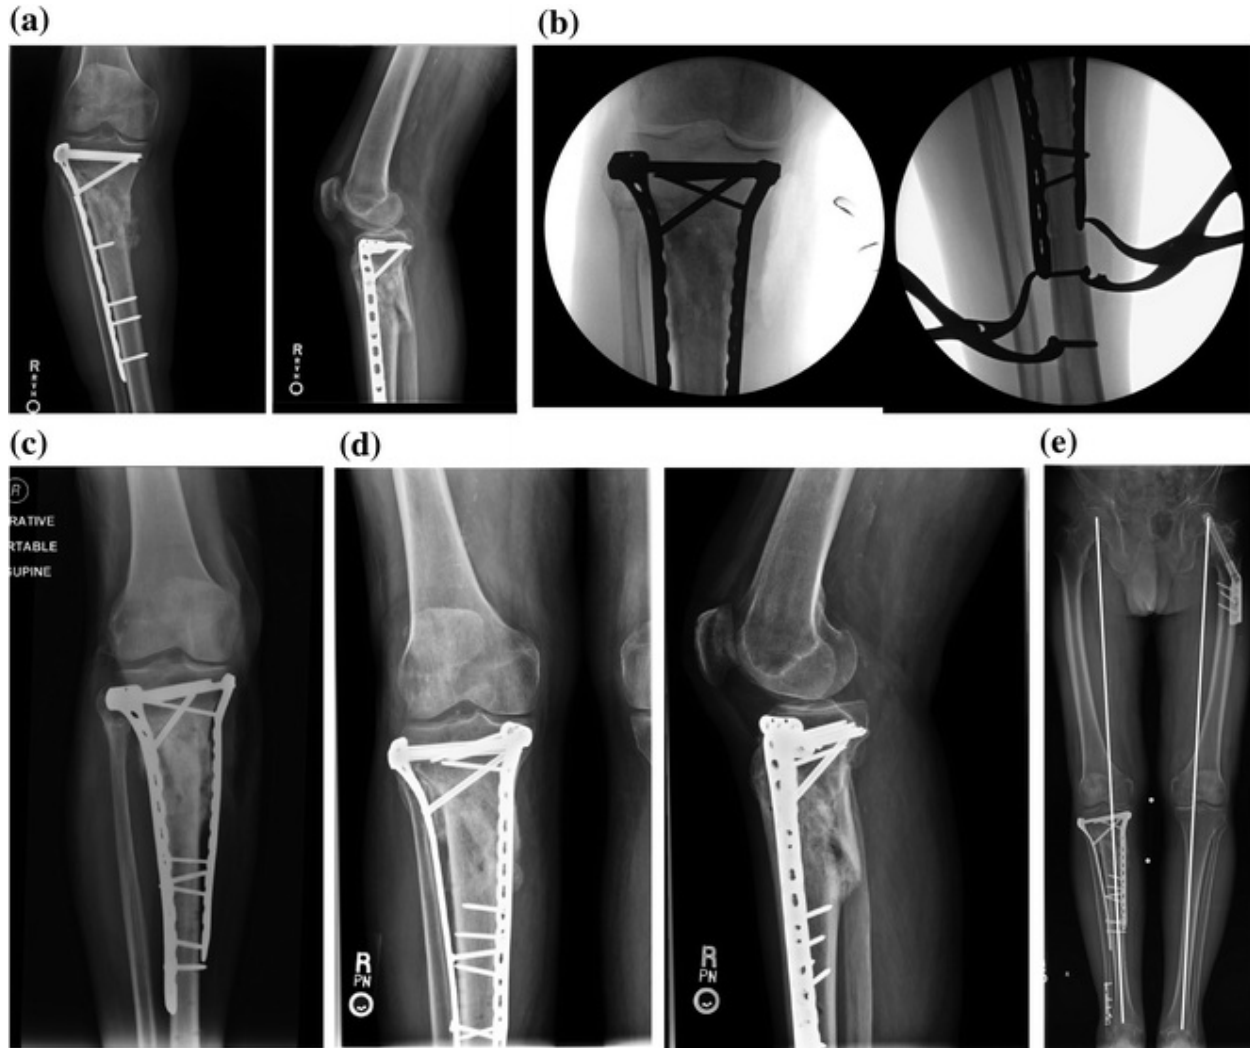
a Presenting films demonstrate varus deformity that was progressive since the time of his initial stabilization in near-anatomic alignment. Sagittal plane alignment appears good. b After establishing locking fixation in the proximal segment medially and laterally, compression and fine-tuning of alignment were achieved with medial and lateral Verbrugge clamps and push-pull screws distally. c Intraoperative plain films are taken on 17" × 14" cassettes to confirm coronal plane alignment with a larger field of view than offered by the fluoroscopy. d After 4 months, osseous union is confirmed radiographically. e Full-length weight-bearing view of the bilateral lower extremities confirms restoration of alignment
